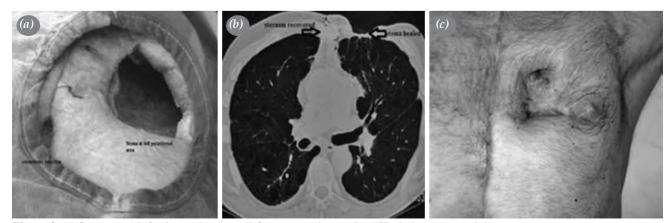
(a) Sternotomy infection and stoma at left parasternal area. (b, c) Healed sternum and thoracostoma.
